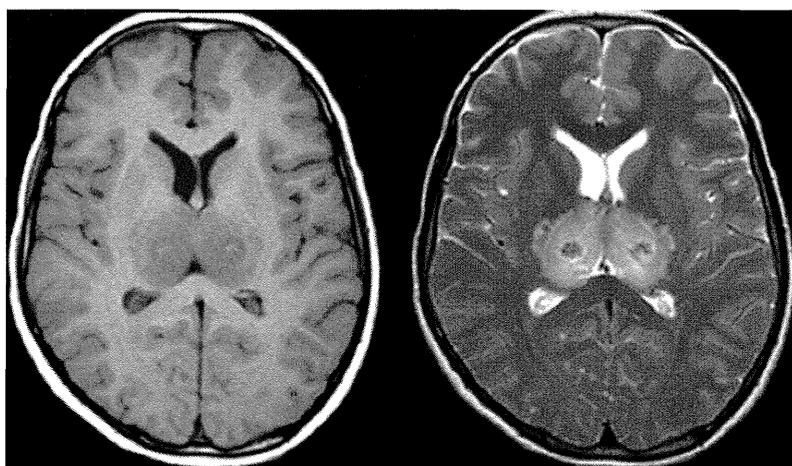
MRI from a 12-year-old boy showing typical findings in ANE. The T1WI (left) and T2WI (right) show concentric lesions in the bilateral thalami and lentiform nuclei. The center and periphery of the thalamic and lenticular lesions show hyperintensity on T1WI (left) and hypointensity on T2WI (right), suggestive of hemorrhagic change.
